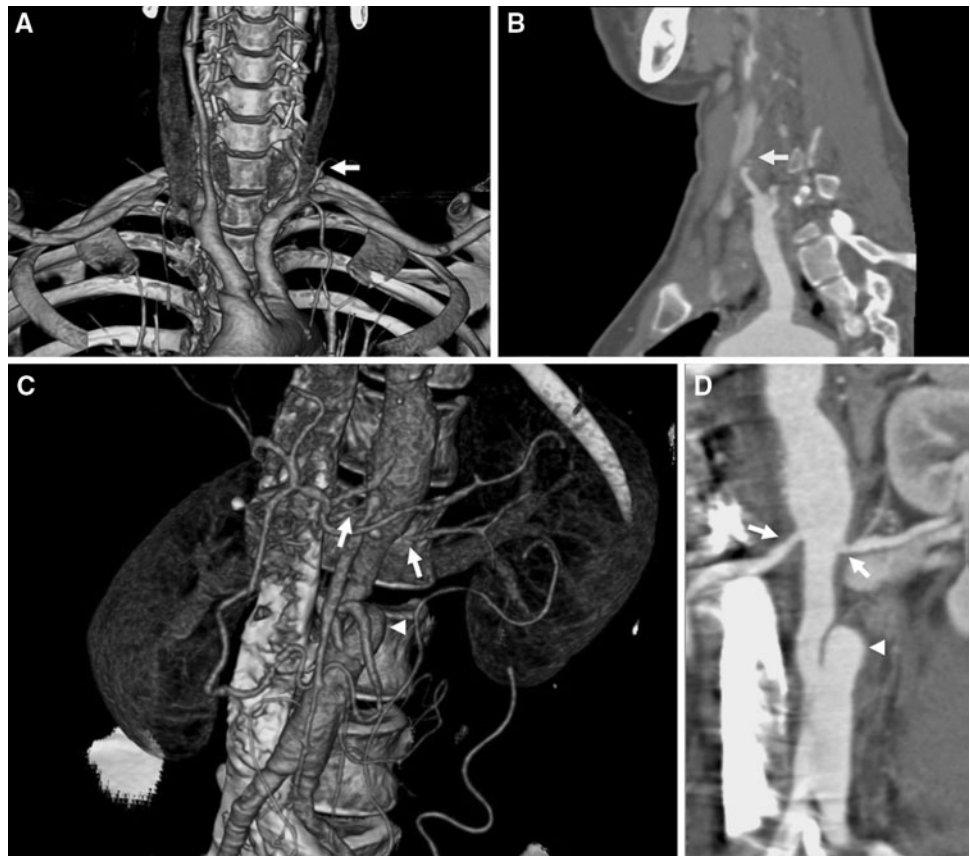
Case 1: three-dimensional computed tomography of aortic arch and abdominal aorta. a, b 3D-CT angiography showing occlusion of left common carotid artery (*arrow*). c, d Stenosis of both renal artery (*arrows*) and focal dissecting aneurysm in the infrarenal abdominal aorta (*arrow head*) by 3D-CT angiography
